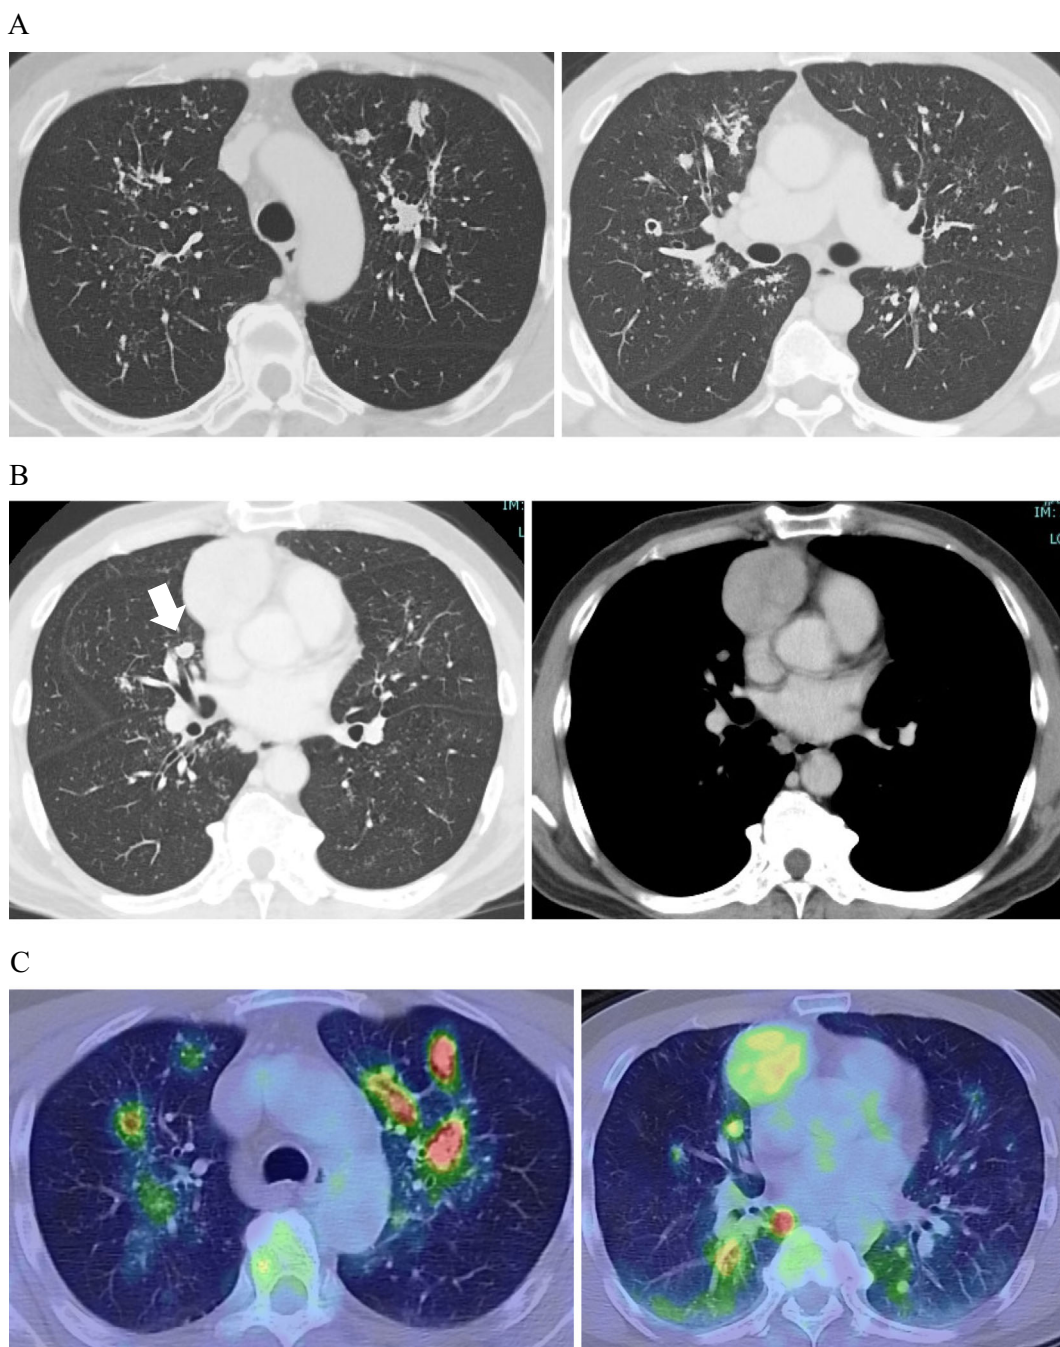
(A, B) Chest CT revealed mildly thickened bronchial walls and diffuse peribronchovascular nodules. The nodules were distributed in the central to middle lung regions of the upper and middle lobes. (B) In the mediastinal window, a well-circumscribed mass was revealed in the anterior mediastinum. The white arrow indicates a nodule removed by a surgical lung biopsy. (C) Positron emission tomography (PET) showed the accumulation of fluorodeoxyglucose in both the mediastinal mass and pulmonary nodules.
